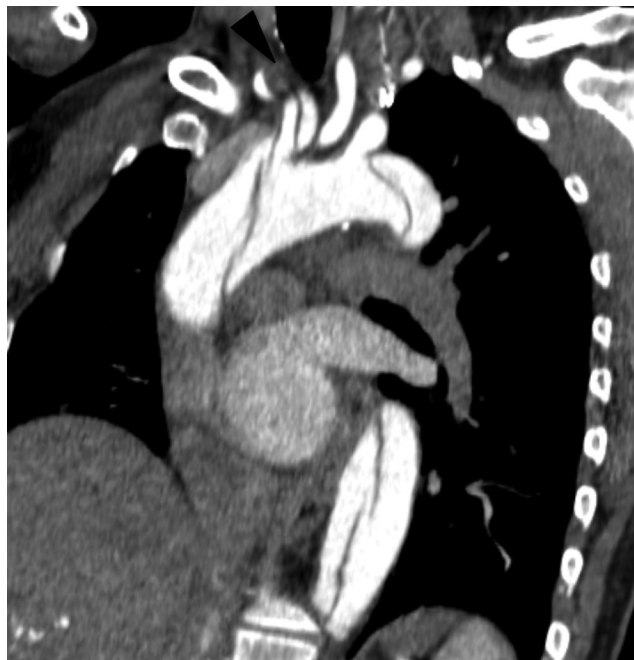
Preoperative computed tomography scan of the aortic arch with intravenous contrast, reformatted image, highlighting subtotal occlusion of right carotid artery compressed by the false lumen (black arrowhead). Note left subclavian artery take-off from true lumen.
